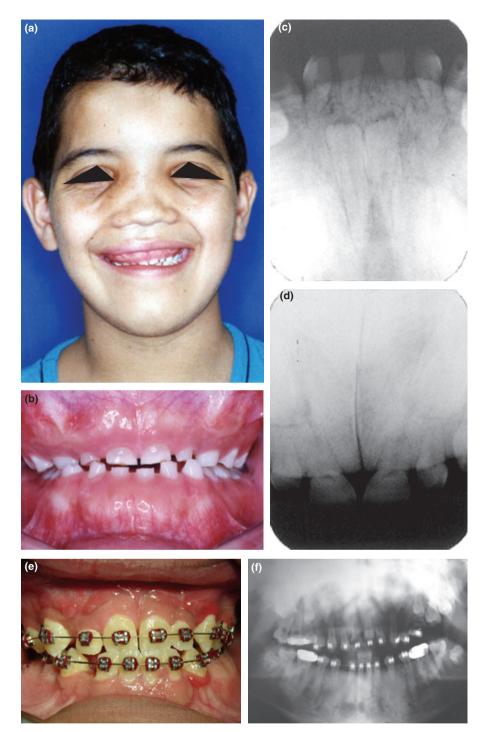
(a, b) Increased bone density: full face and anterior deciduous dentition. (c, d) Periapical views of anterior teeth to show extreme bone density. (e, f) Clinical and panoramic progress views after 3.1 years of treatment.
